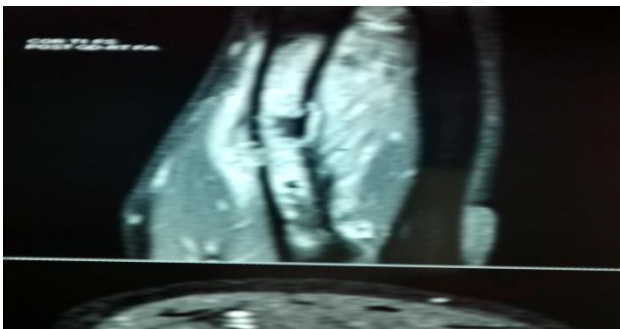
MRI showing chronic osteomyelitis.
